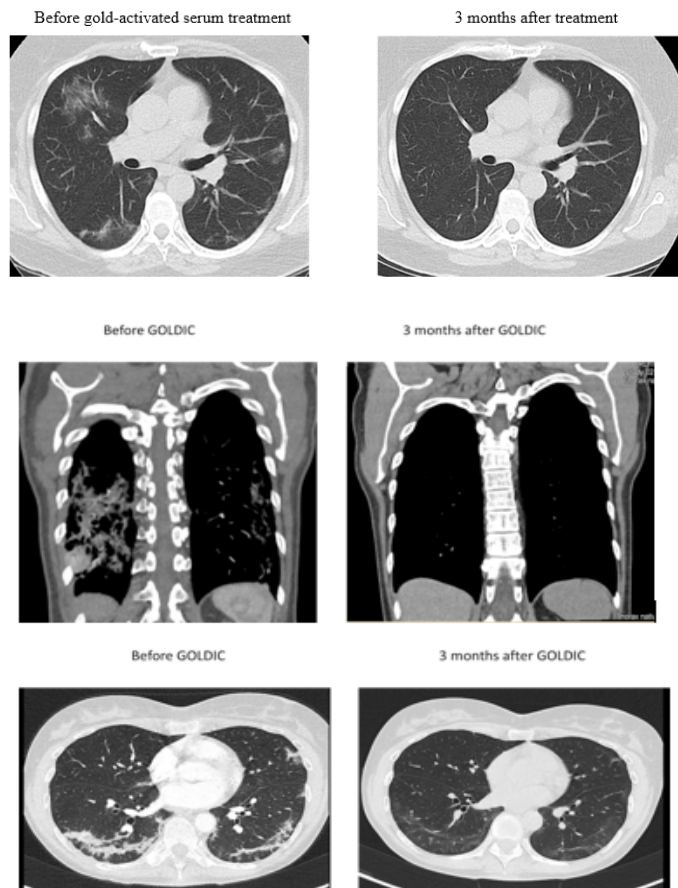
Radiological documentation of a “Long-Covid” patient before and 3 months after treatment with gold-activated serum documented by CT-scan. The infiltration in both lungs disappeared completely. 4b: Radiological documentation of another “Long-Covid” patient before and 3 months after treatment with gold-activated serum documented by CT-scan. The post infective destruction mostly in the right lung was regenerated after the treatment.
